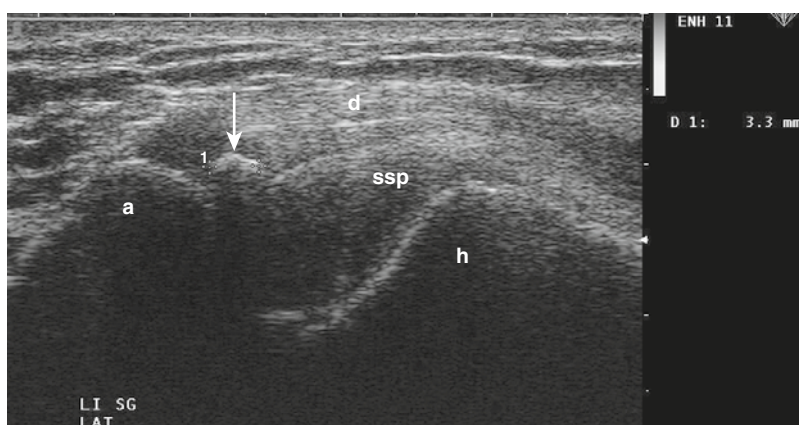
Ultrasound delineates calcification (arrow) of the supraspinatus tendon in a lateral longitudinal scan. a, acromion; d, deltoid muscle; h, humeral head; ssp, supraspinatus tendon.
